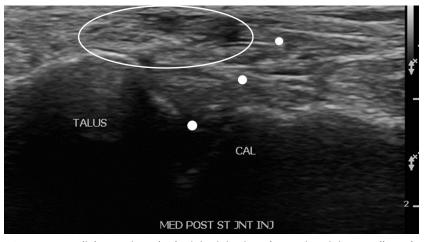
Posteromedial posterior subtalar joint injection, short axis to joint, needle path out of plane with transducer. Oval encircles the tibial neurovascular structures. Dots represent path of needle. Each dot signifies a pass of the needle tip below the ultrasound beam. The needle is directed along a steeper trajectory with each pass until the tip is visualized within the joint space. Left, superior; right, inferior. CAL, calcaneus.
